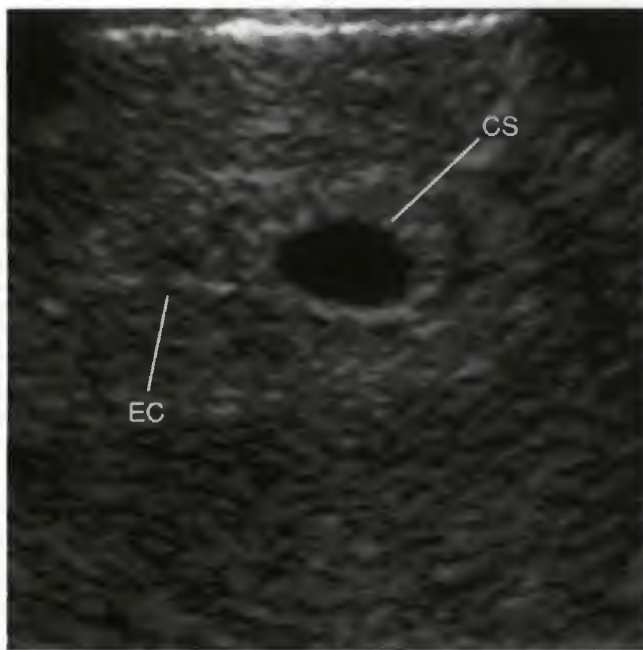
The double decidual sac sign is a misnomer. This sonographic feature typical of early gestations simply should be called the double sac sign because of the origin of only one of the decidia. The origin of the inner of the double rings (the endometrial cavity [EC]) is less echogenic than the deeper layer (closer to the myometrium). It is the less echogenic superficial layer of the decidua vera (DV) that provides the "separation" between the more echogenic chorionic villi (C) and deeper decidua vera rings.
